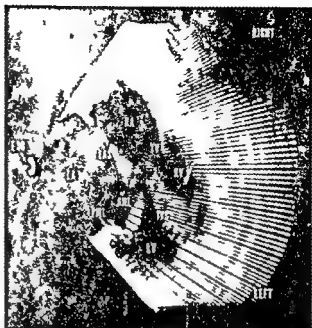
Transesophageal horizontal sector scan during diastole at the level of the mitral and tricuspid valves in a patient with severe mitral stenosis. Tricuspid valve, mitral valve, ventricles and atria are seen. Anterior and posterior mitral leaflets are thickened. ESO = esophagus LA = left atrium RA = right atrium L = left ventricle R = right ventricle IAS = interatrial septum IVS = interventricular septum AVL = anterior mitral leaflet PVL = posterior mitral leaflet TV = tricuspid valve.
